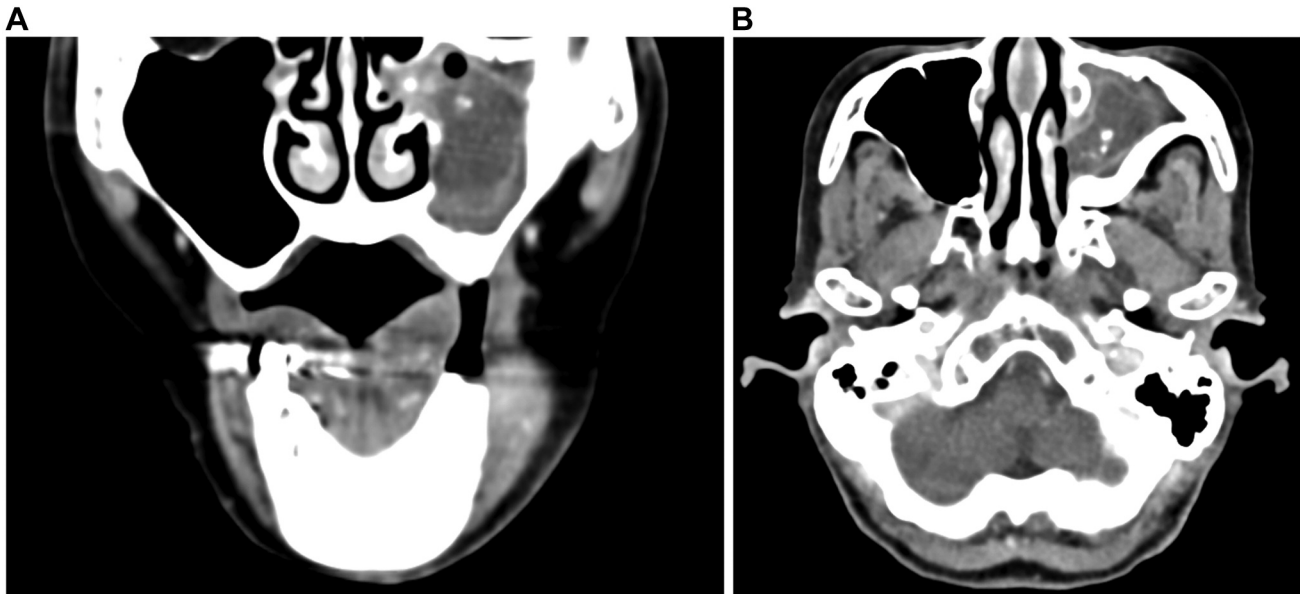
(A) CT-scan in a coronal section showing a completely obstructed maxillary sinus on the left due to a polypoid mass. The mass shows ring-shaped enhancement of contrast medium typical of aspergillomas. (B) CT-scan in an axial section showing the extent and the typical contrast agent enhancement of the aspergilloma. CT: Computed tomography.
